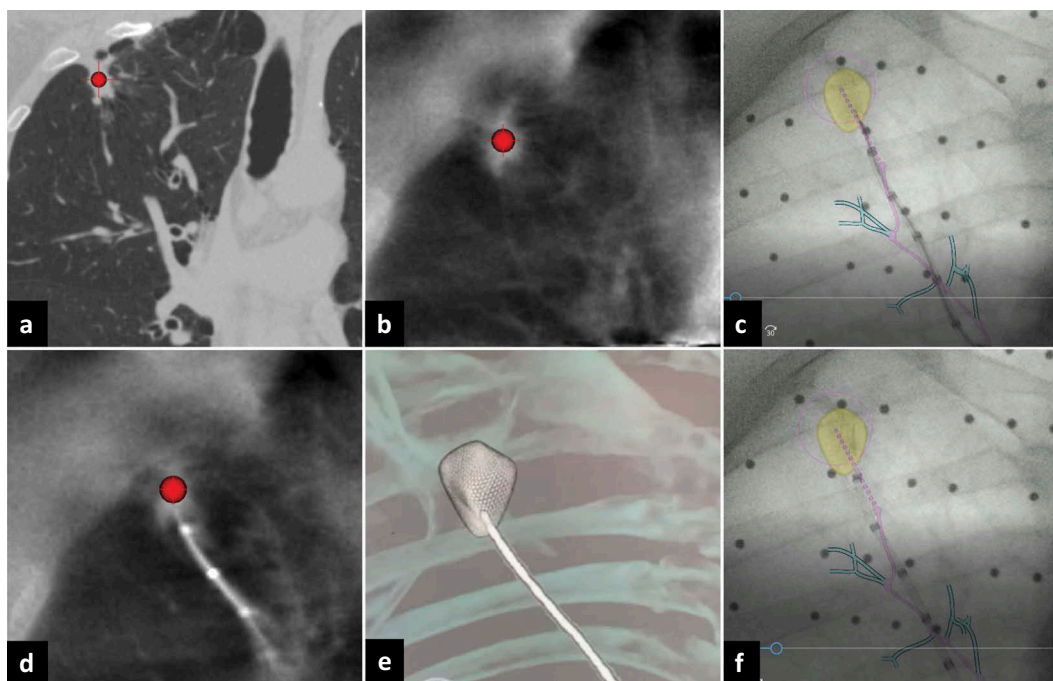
Fluoroscopic navigation using the LungVision platform (BodyVision Medical). The target lesion (red sphere) is identified on CT images using proprietary planning software (a). During bronchoscopy, fluoroscopy C-arm-based tomography (CABT) is used to resolve the lesion that is otherwise occult on conventional two-dimensional fluoroscopy (b). LungVision software fuses data from the planning CT, CABT, and intraprocedural fluoroscopy to provide a pathway to the lesion in real-time, and the proceduralist navigates along this pathway using a proprietary catheter under augmented fluoroscopic guidance until the lesion is reached (c). At the end of the navigation, CABT is repeated to confirm that the navigation catheter is within the lesion (d, e), after which tissue-sampling is performed under augmented fluoroscopic guidance (f). *Images reproduced with permission from Dr. Joseph Cicensia.*
